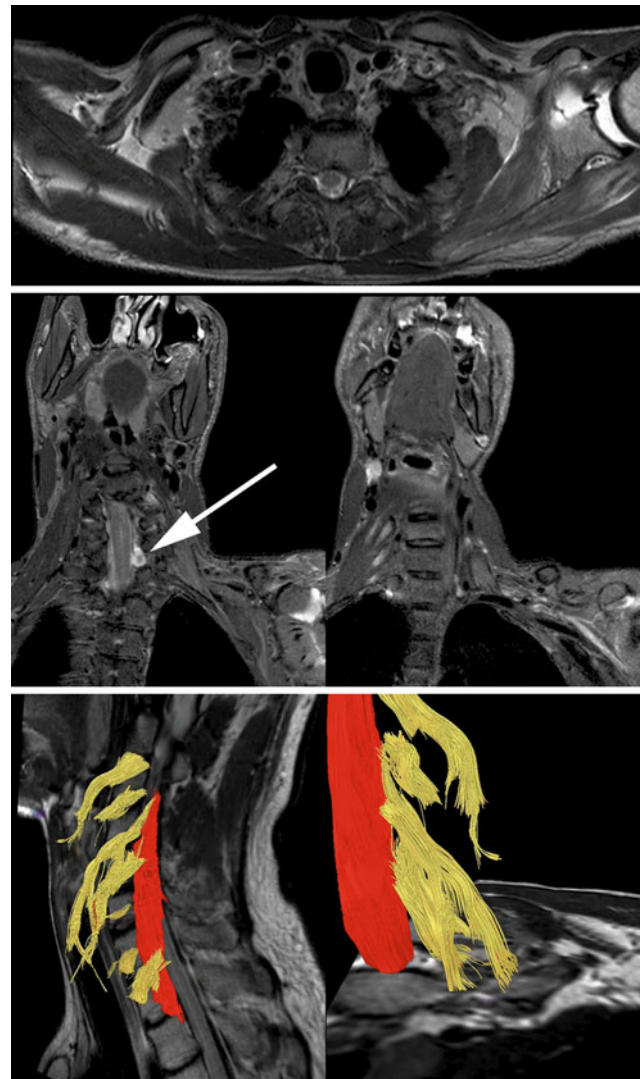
Axial T2-weighted (*upper row*), paracoronal STIR (short tau inversion recovery) (*middle row*), and tractography images in a patient with a complete posttraumatic (fall from great height) brachial plexus paresis: In addition to the posttraumatic effusion of the glenohumeral joint, signal alterations of left sided subscapular and infraspinatus muscle are detected. The pattern of these signal alterations follows a characteristic distribution, typical for muscle denervation after brachial plexus injuries. The paracoronal STIR sequences show denervation edema of the middle and posterior scalenus muscles as well as the retracted distal nerve segments of the ruptured brachial plexus nerves. This finding is visualized in 3D by tractography (*lower row*). Moreover, diffusion tensor imaging (DTI) could not visualize the distal segments of the avulsed nerve root C7 and C8 (*arrow points to pseudomeningocele*), due to loss of anisotropy and Wallerian degeneration
